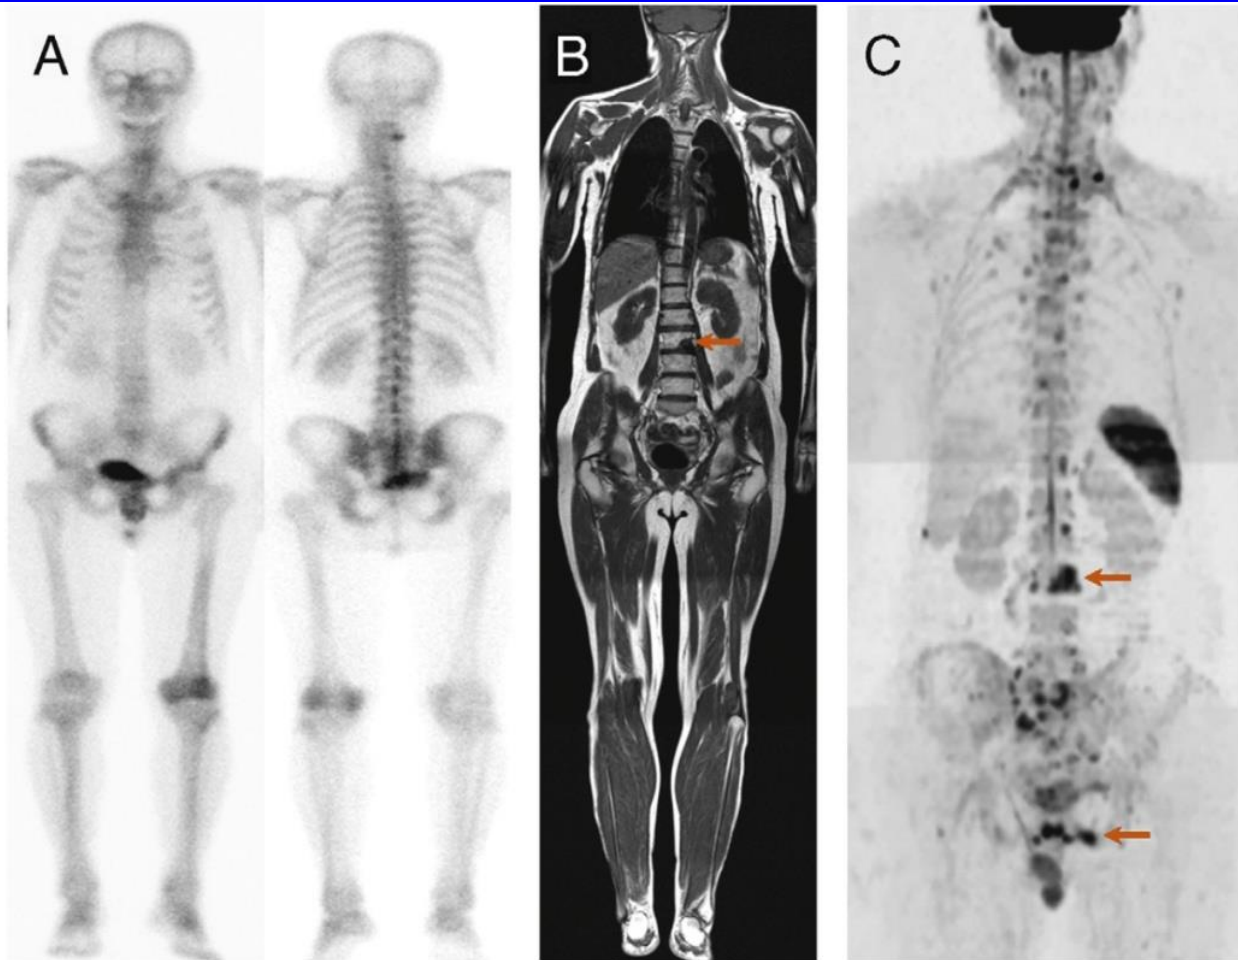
Whole-body magnetic resonance imaging (MRI) versus false-negative bone scintigraphy (BS) for bone metastasis detection in a 65-yr-old patient with newly diagnosed prostate cancer (prostate-specific antigen 18 ng/ml; Gleason score 7 [4 + 3]). (A) BS (anterior-posterior and posterior-anterior views) shows no significant lesion. (B) Coronal T1 and (C) diffusion-weighted MRI images of the whole body confirm bone metastases within L3 and the left iliac bone (arrows).
